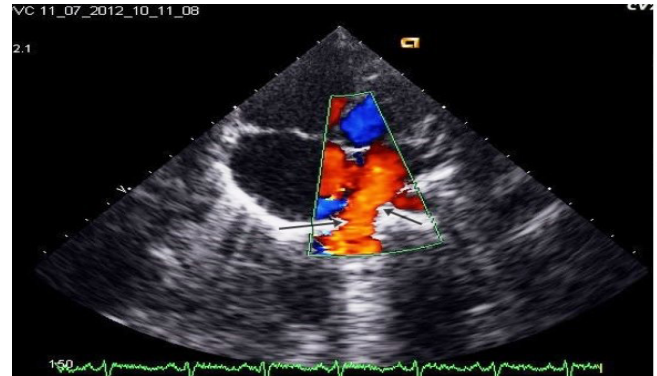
2D Echocardiography with apical 4 chamber view showing right lower pulmonary vein draining into left atrium [arrow marks]
